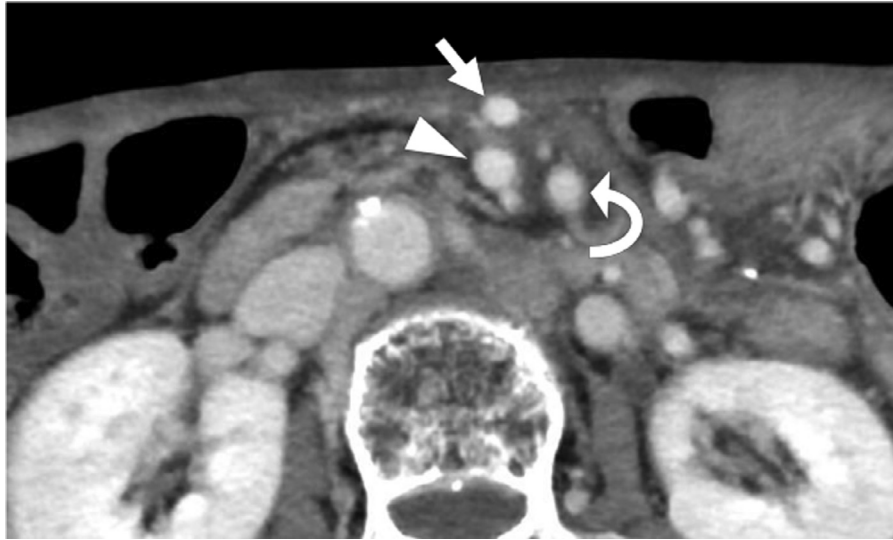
Contrast-enhanced computed tomography scan of the upper abdomen reveals that the middle colic vein (arrow) is dilated. The superior mesenteric vein (arrowhead) and the superior mesenteric artery (curved arrow) can also be appreciated in the scan
